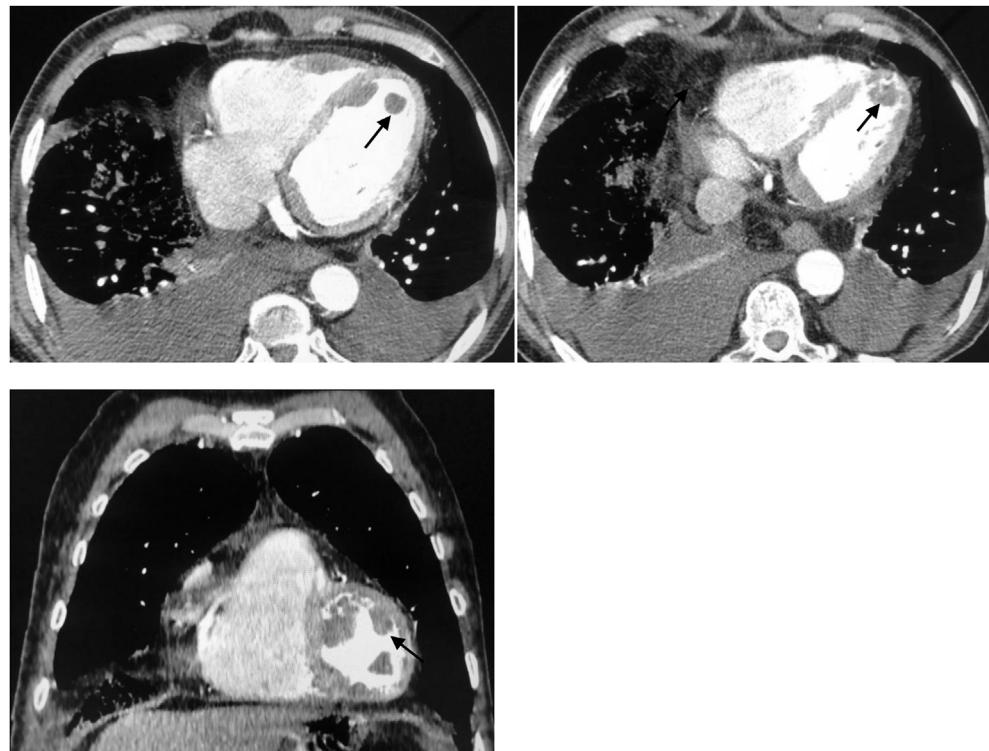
Pulmonary computed tomography angiography images in the axial and coronal planes showing thrombus in left ventricle (arrow).
